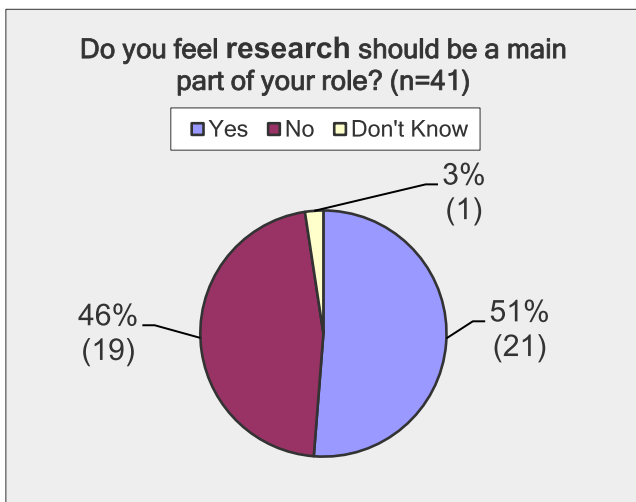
Should research be a core domain of consultant radiographic practice?
